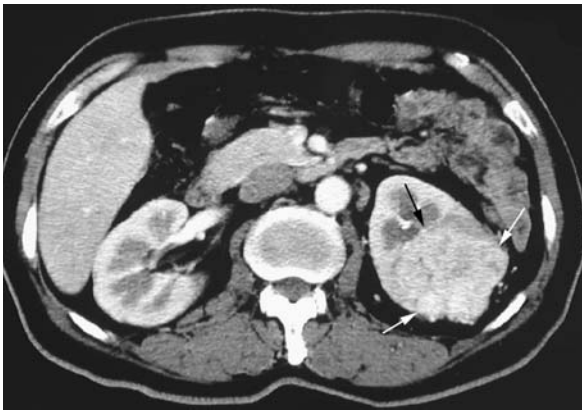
Renal plasmacytoma in a 58-year-old man without bone marrow evidence of multiple myeloma. Axial contrast-enhanced CT scan shows a heterogeneously enhancing mass (*arrows*) arising from the left kidney.
